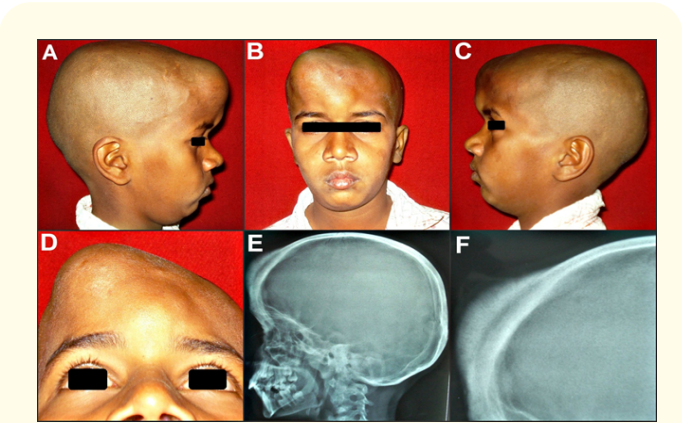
(A, B, C, D) A 11 year old male patient with a large dome-shaped, bony hard swelling in the right anterior aspect of the frontal bone, extending from the coronal suture region to the right supraorbital rim and bridge of the nose. (E) Lateral view skull radiograph, revealing a diffuse radio-opaque thickening and hyperostosis of the outer cortical table of the frontal bone, with an enlarged and hazy diploeic space. (F) A typical “Ground glass” radio-opacity with features of a “sun-ray”/“sunburst” appearance towards the periphery.
